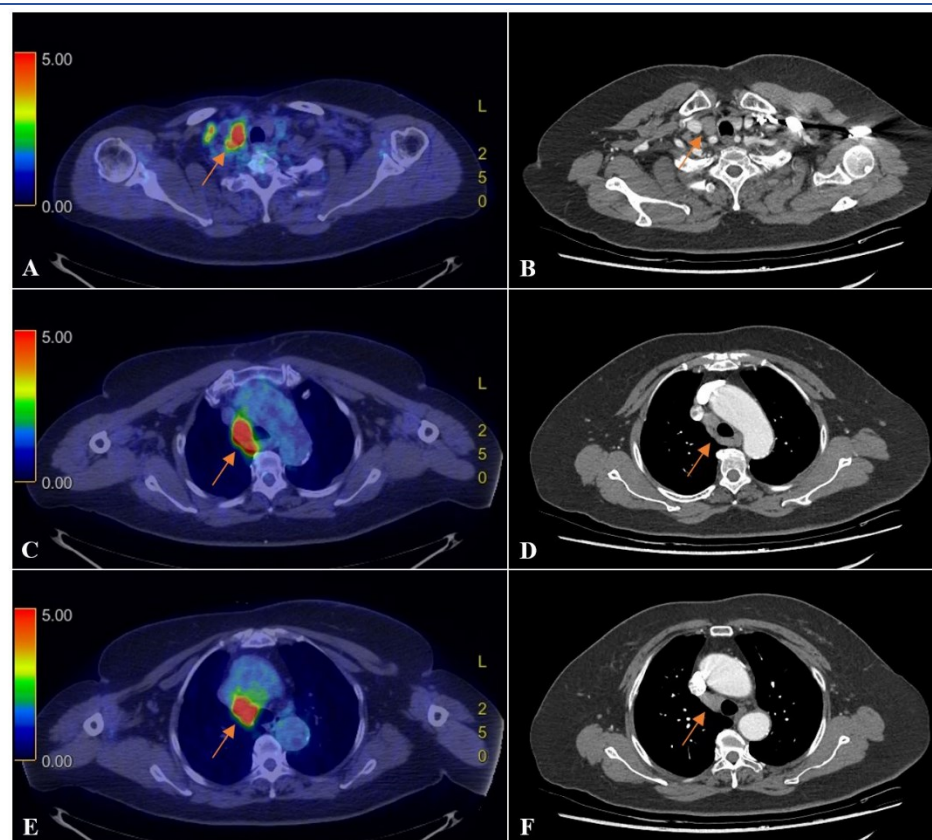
[^{18}F]FDG PET/CT reveals hypermetabolic lymphadenopathies (SUVmax of 10.8) in the right supraclavicular area (A), right upper paratracheal area (C) and right lower paratracheal area (E). Chest CT also demonstrates enlarged lymph nodes in the corresponding sites (B, D, F). These lesions were diagnosed as tuberculous lymphadenitis through biopsy and interferon-gamma release assay
